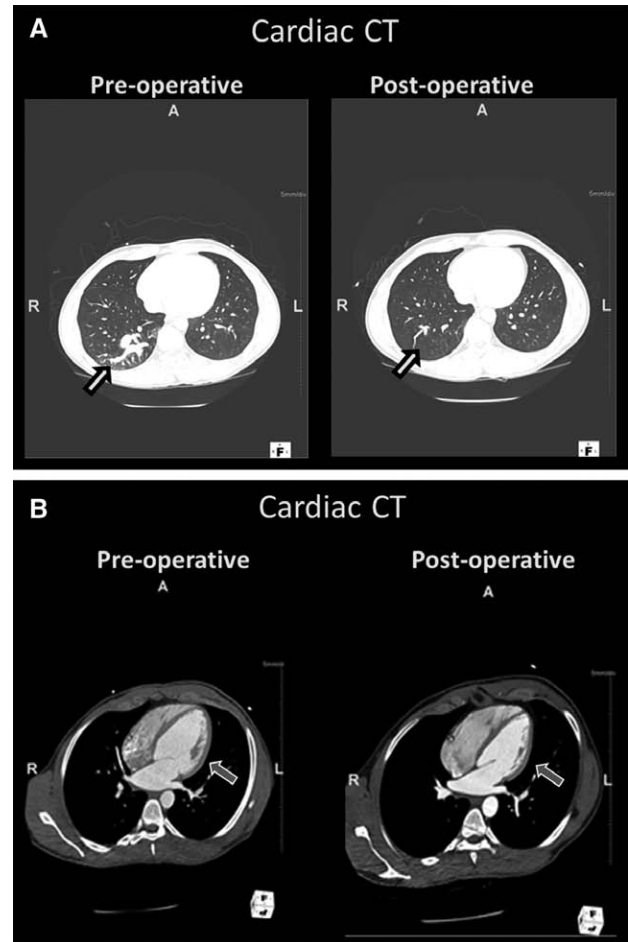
A, Presurgical cardiac computed tomography (CT) images demonstrating a fistula within the posterior right lower lung lobe (yellow arrow). Postsurgical cardiac CT shows normal lungs after successful ligation of the fistula. B, Presurgical cardiac CT images demonstrating dilated left ventricle (red arrow). Postsurgical cardiac CT shows a reduction in the size of the left ventricle after successful ligation of the fistula.
